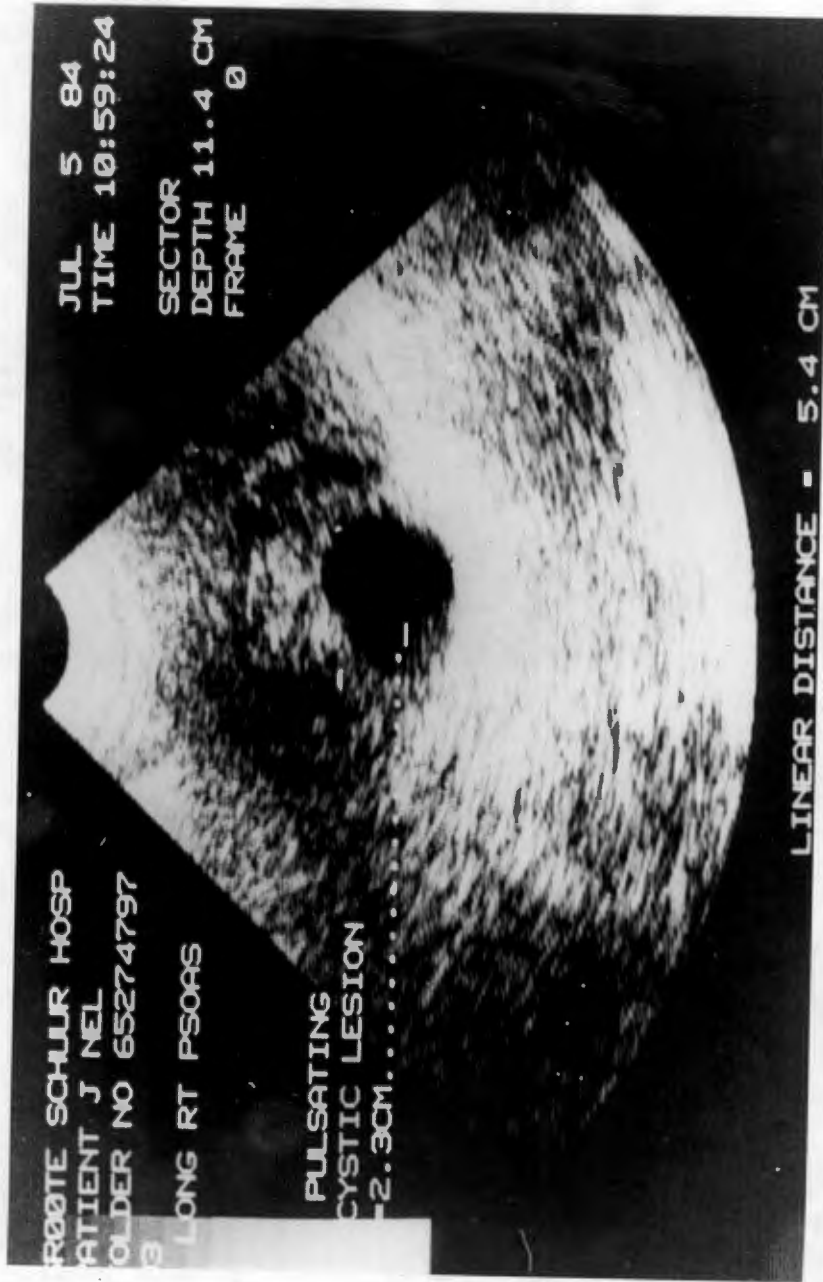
Ultrasound study demonstrating the false aneurysm.
